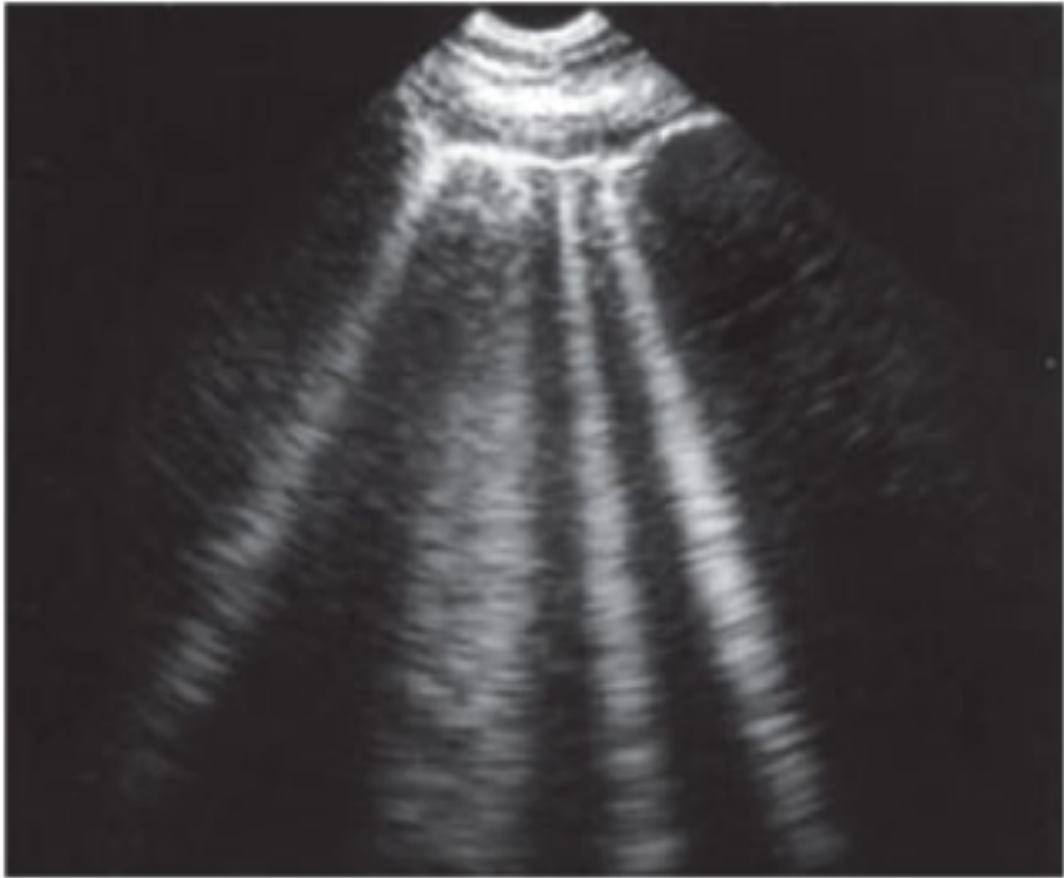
B-lines on lung ultrasound. Although B-lines are seen in normal individuals, the number and intensity of B-lines are directly proportional to the degree of pulmonary, septal or alveolar edema.
